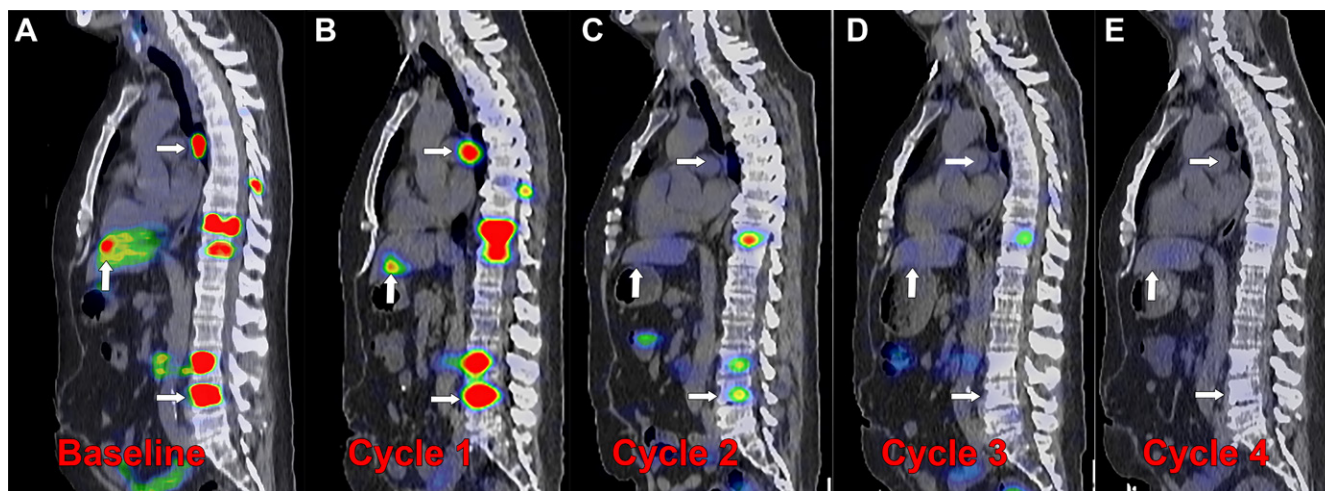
Posttherapy monitoring of index lesions with SPECT/CT imaging. Fused SPECT/CT sagittal images in a 56-year-old man with prostate-specific membrane antigen (PSMA)-avid metastatic prostate cancer undergoing lutetium 177 (^{177}Lu) PSMA-617 therapy. (A) Baseline fluorine 18 (^{18}F) carboxy-fluoro-pyridine-carbonyl-amino-pentyl-ureido-pentanedioic acid (DCFPyl) PET/CT image demonstrates intense PSMA uptake in nodal, osseous, and hepatic metastases (arrows). (B–E) Posttherapy SPECT/CT image with ^{177}Lu -PSMA-617 was performed approximately 24 hours after infusion of the therapeutic radiotracer after each of four cycles administered 6 weeks apart, demonstrating localization of the therapeutic radiopharmaceutical to the metastases. Index lesions in lymph node, bone, and liver (arrows) demonstrate decreased intensity of uptake with each cycle of therapy. (C) After cycle 2, the hepatic and nodal metastases were no longer conspicuous, and (E) after cycle 4, the spine metastasis was no longer conspicuous. Imaging the therapeutic radionuclide enables confirmation of effective delivery to the sites of cancer and detection of treatment response over the course of therapy, demonstrated by the changes in the imaged index lesions over time.
